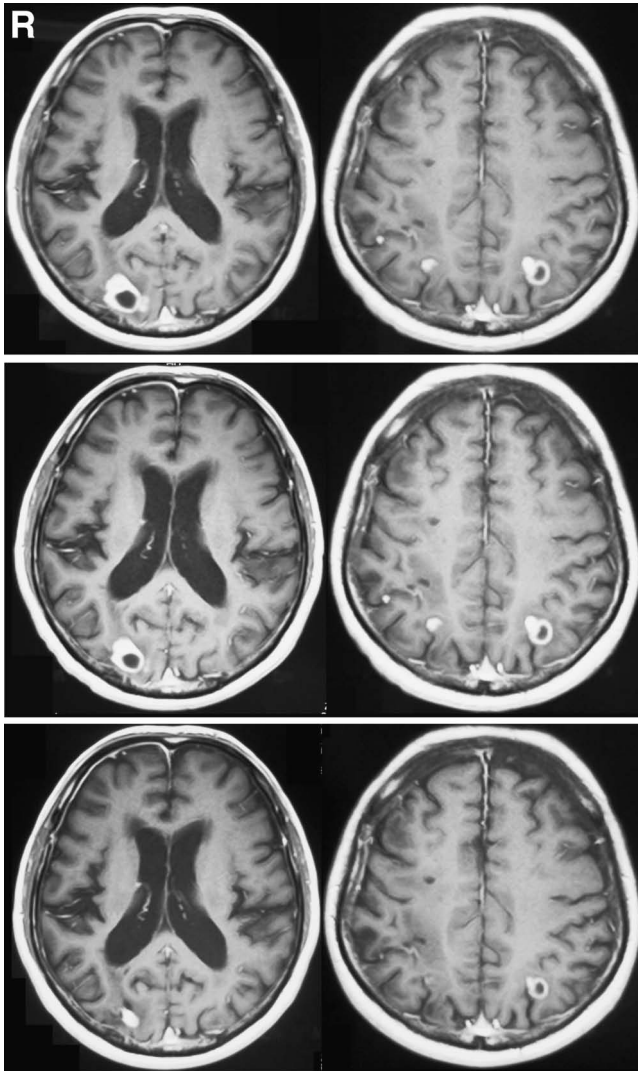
Serial postcontrast T₁-weighted magnetic resonance images before (upper row), 3 month after (middle row), and 9 months after gamma knife radiosurgery (lower row) demonstrating significant tumor regression and even disappearance of some tumors.
